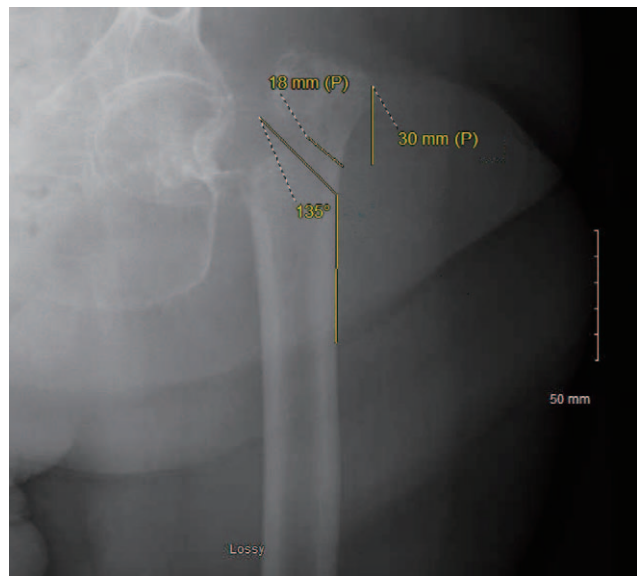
Anteroposterior radiograph of the left hip demonstrating a thin lateral wall measured using a standard method.
